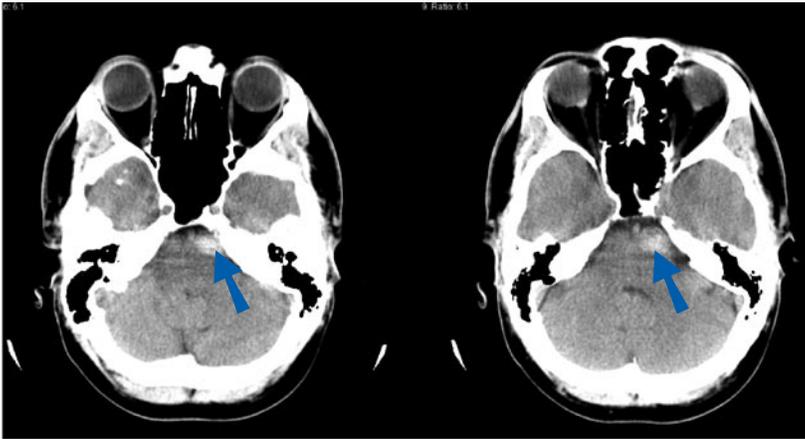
A and B. Initial head CT reveals hyperdensity of the left anterolateral pons, consistent with acute hemorrhage.
